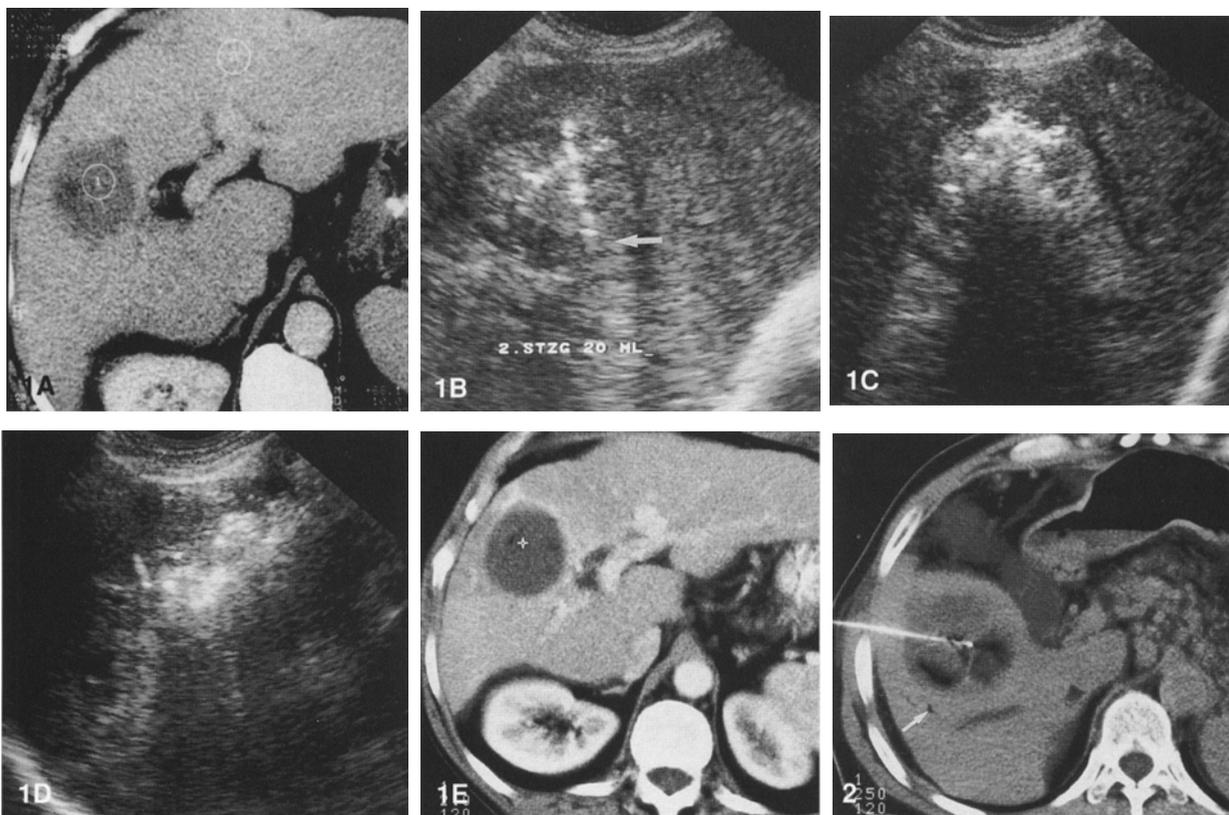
US-guided percutaneous ethanol injection (PEI) of hepatocellular carcinoma (HCC) and follow-up with CT. A Contrast enhanced CT scan (venous phase) shows a hypoattenuating mass 5 cm in diameter within the right hepatic lobe corresponding to a single HCC nodule. B On US, the mass is hyperechogenic and well defined. A special 21 gauge needle with multiple side holes but no end hole (Ago Pia, Milan, Italy), has been inserted under US guidance; the position of the needle tip close to the posterior border of the lesion (arrow) indicates that the side holes are in an appropriate position. C Injection of ethanol causes echogenic artifacts within the lesion and acoustic shadowing due to microbubbles, thus allowing real-time monitoring of the distribution of ethanol. D After injection of 20 ml of ethanol, the lesion becomes obscured by these artifacts. E Contrast enhanced spiral CT (venous phase) obtained 24 hr later demonstrates the effect of PEI. The smooth, regular, enhancing rim around the nonenhancing tumor persisting in the venous phase was interpreted as reactive hyperemia rather than residual tumor. No further treatment was given. There was no evidence of residual tumor or local tumor recurrence on follow-up.
